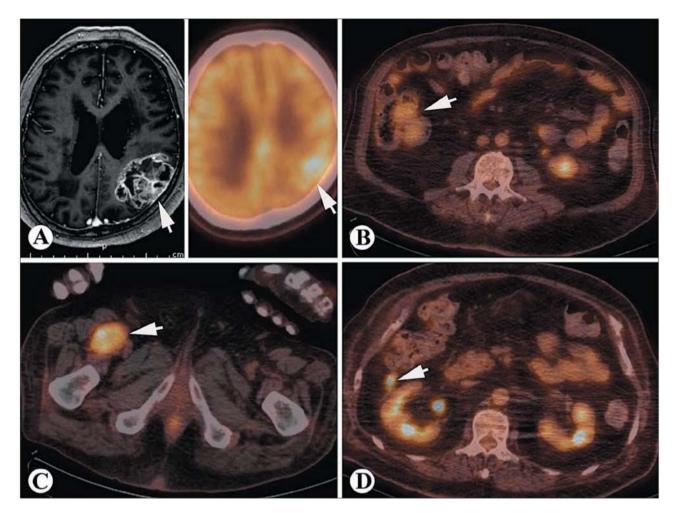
Radiologic examination of the four primary lesions. (A) An MRI with contrast turbo-field echo (TFE) and sensitivity encoding (SENSE) of the glioblastoma (white arrowhead) shows diffuse T1 and T2 enhancement with internal susceptibility consistent with blood products and/or calcification (left) and FDG-PET/CT of the glioblastoma (white arrowhead) showing intense FDG uptake with SUV<sub>max</sub> 11.9 (right); (B) FDG-PET/CT of the NET (white arrowhead) near the ileocecal valve showing increased FDG uptake with SUV<sub>max</sub> 3.7; (C) FDG-PET/CT of the inguinal schwannoma (white arrowhead) showing intense FDG uptake with SUV<sub>max</sub> 11.8; (D) FDG-PET/CT of the appediceal SSA/P (white arrowhead) showing intense FDG uptake with SUV<sub>max</sub> 7.1.
